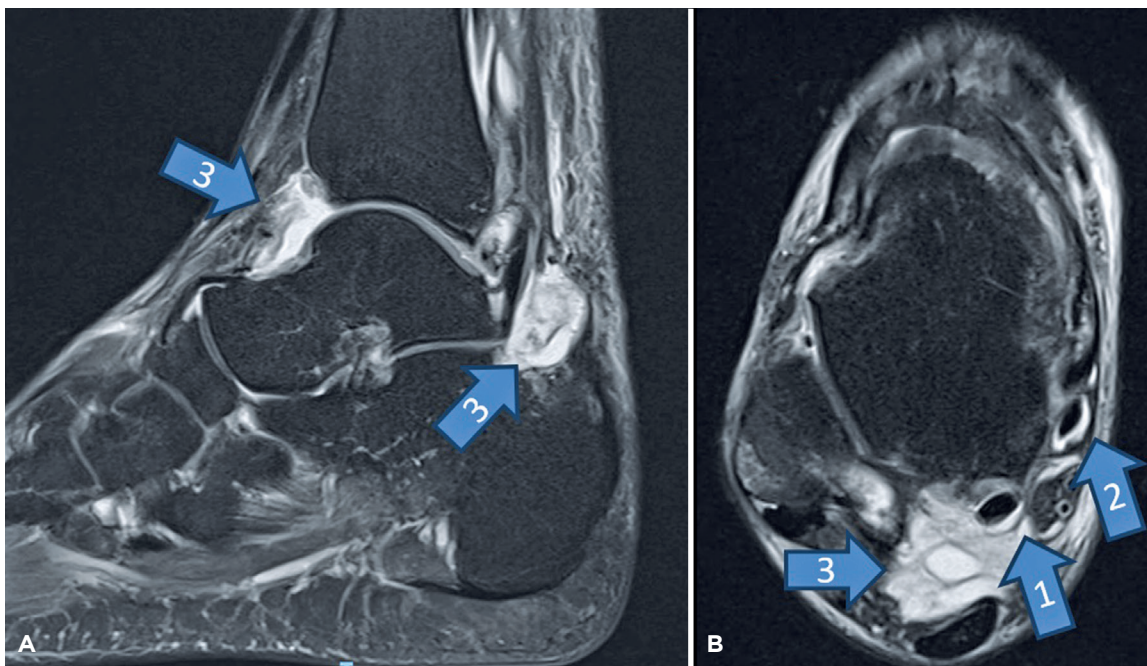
Ankle T2-weighted sagittal (A) and axial (B) magnetic resonance imaging showing improvement of flexor hallucis longus (arrow n. 1) and posterior tibial tenosynovitis (arrow n. 2). No nodules were present but a collection of about 2 cm, with high signal intensity, compatible with infection (arrow n. 3).
